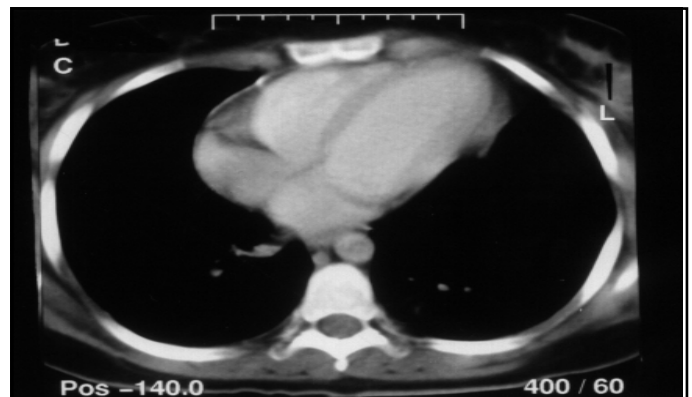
Computed tomography. There was no significant pericardial effusion 6 months after intrapericardial instillation of cisplatin.
